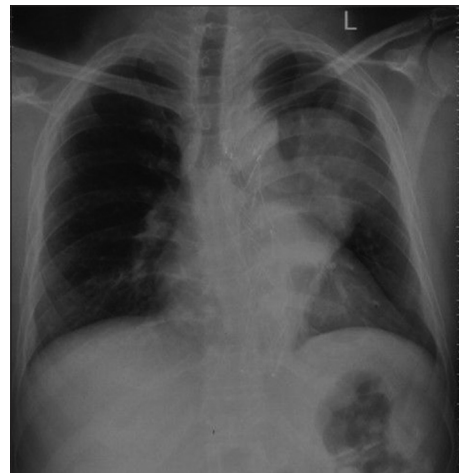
Posteroanterior chest radiograph raising a suspicion of left hilar mass
